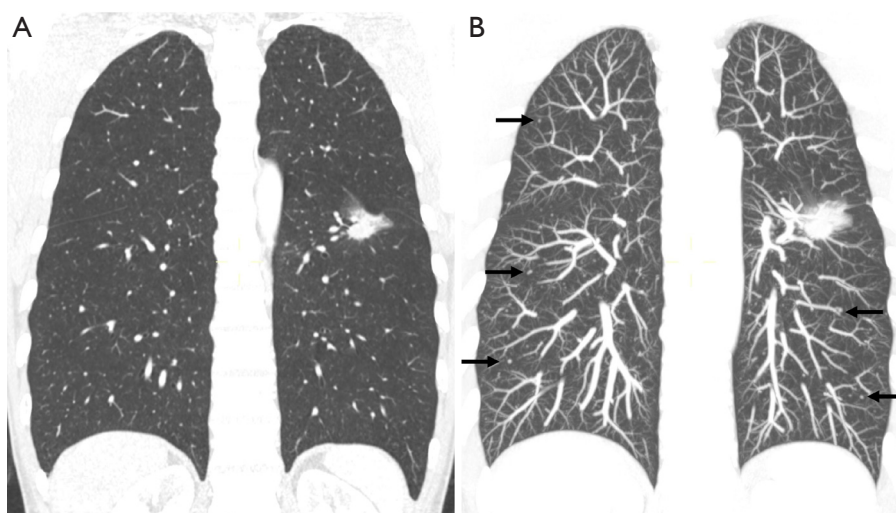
Example of lung lesions that are easily missed on chest CT. (A,B) A 52-year-old male with adenocarcinoma of the left lower lung lobe. (A) The radiologist reported the main lesion in the left lung but failed to identify multiple small pulmonary nodules, which are difficult to distinguish from cross-sections of blood vessels. (B) The use of MIP reconstruction enhanced the clarity of the visualization of small nodules (black arrows). Subsequently, follow-up of the pulmonary nodules confirmed metastasis. As there is contralateral metastasis, according to the 8th edition Lung Cancer Staging classification (13), it is classified as M1. CT, computed tomography; MIP, maximum intensity projection.
